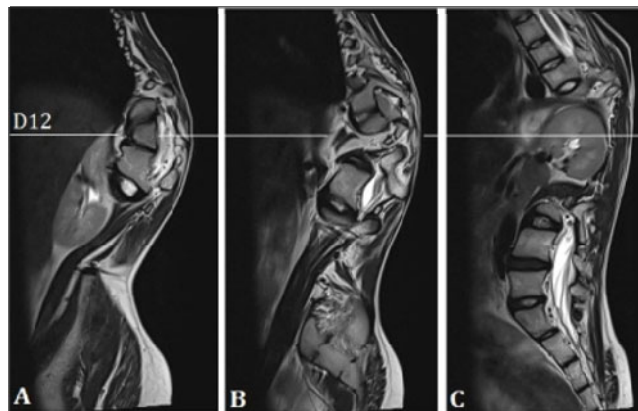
Preoperative serial Magnetic Resonance Imaging (sagittal view) of spine showing D12 right hemivertebra with resultant gross kyphoscoliotic deformity with right sided convexity (line drawn at D12 level). Spinal cord is stretched along the deformity. Compensatory curves are seen.
